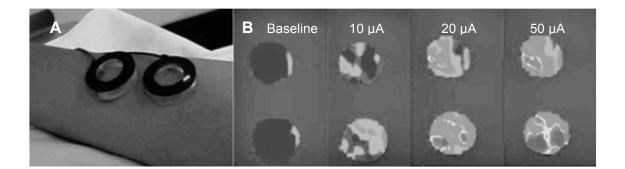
Laser Doppler imaging in combination with iontophoresis. Iontophoresis chambers are positioned on a proband's forearm (A). Microvascular response to sodium nitroprusside (upper images) and acetylcholine (lower images) as measured by laser Doppler imaging are depicted at baseline and in with increasing electric currents applied to the iontophoresis chamber (B). The figure was adapted from Khan [153].
